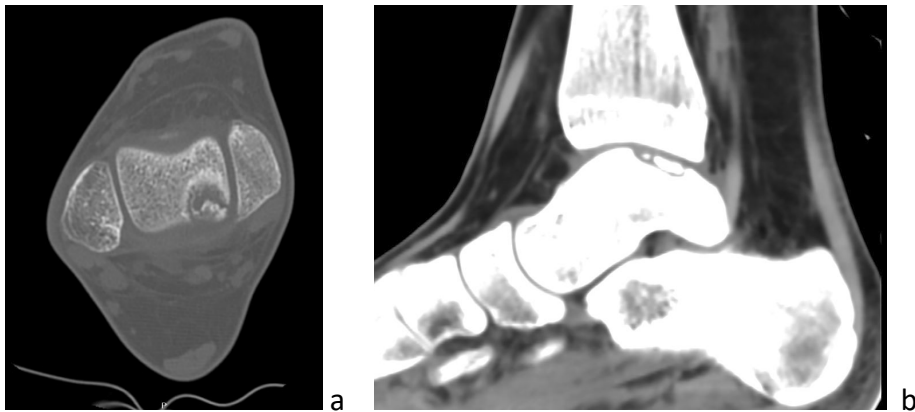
CT. 32-a coronal view, 32-b lateral view
